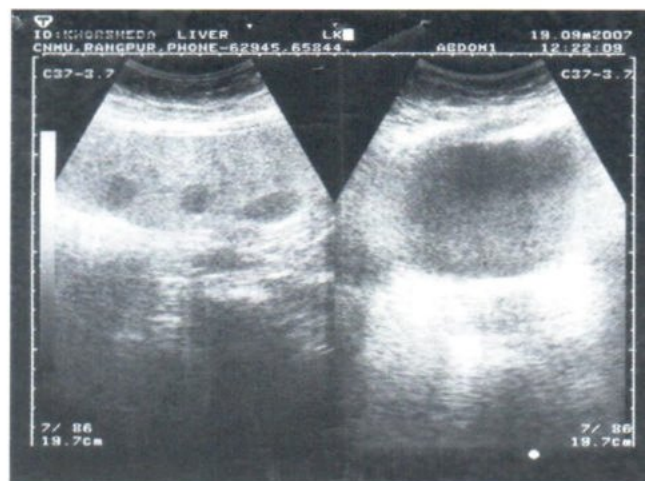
Ultrasonography of liver showing three cyst-like metastases.
